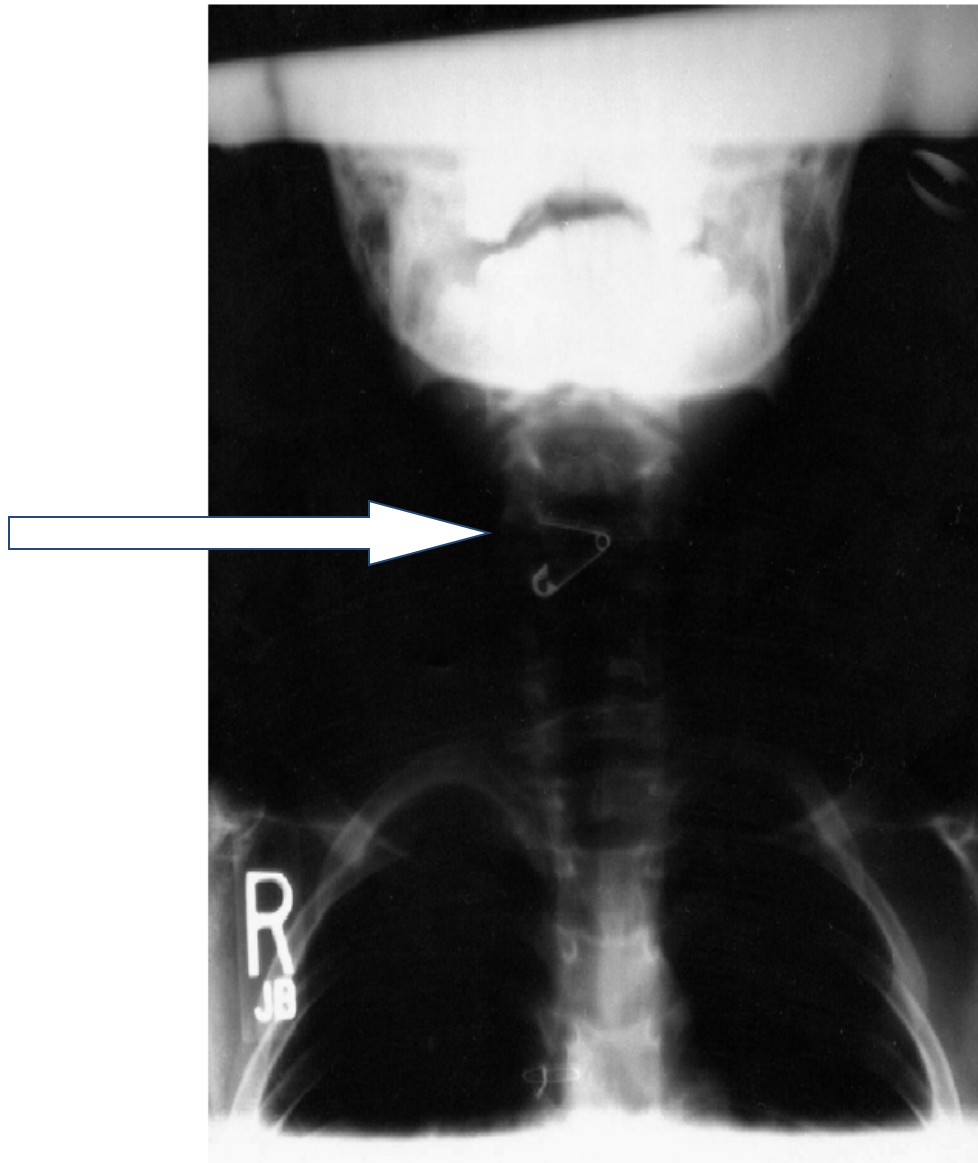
X-ray showing physical evidence of the severity of Tod's pica (Reprinted with permission from Roane, H. S., Fisher, W. W., Call, N. A., & Kelley, M. E. (2005). Self-injury, aggression and pica. In I. L. Rubin & A. C. Crocker (Eds.), *Developmental disabilities: delivery of medical care for children and adults* (p. 506). Baltimore, MD: Brooks Publishing).
